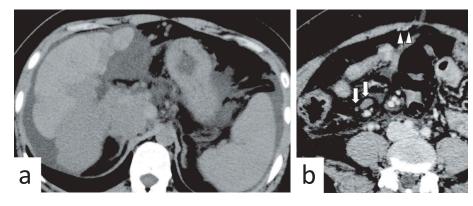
Abdominal contrast-enhanced computed tomography (CT) findings: Contrast-enhanced CT showed atrophy of the liver with a mixed density area, which is likely fatty infiltration or hyperplasia and splenomegaly (a). CT showing a dilated paraumbilical vein with collateral circulation (arrowheads) and lymphadenopathy involving the peri-portal vein (arrows) (b).
